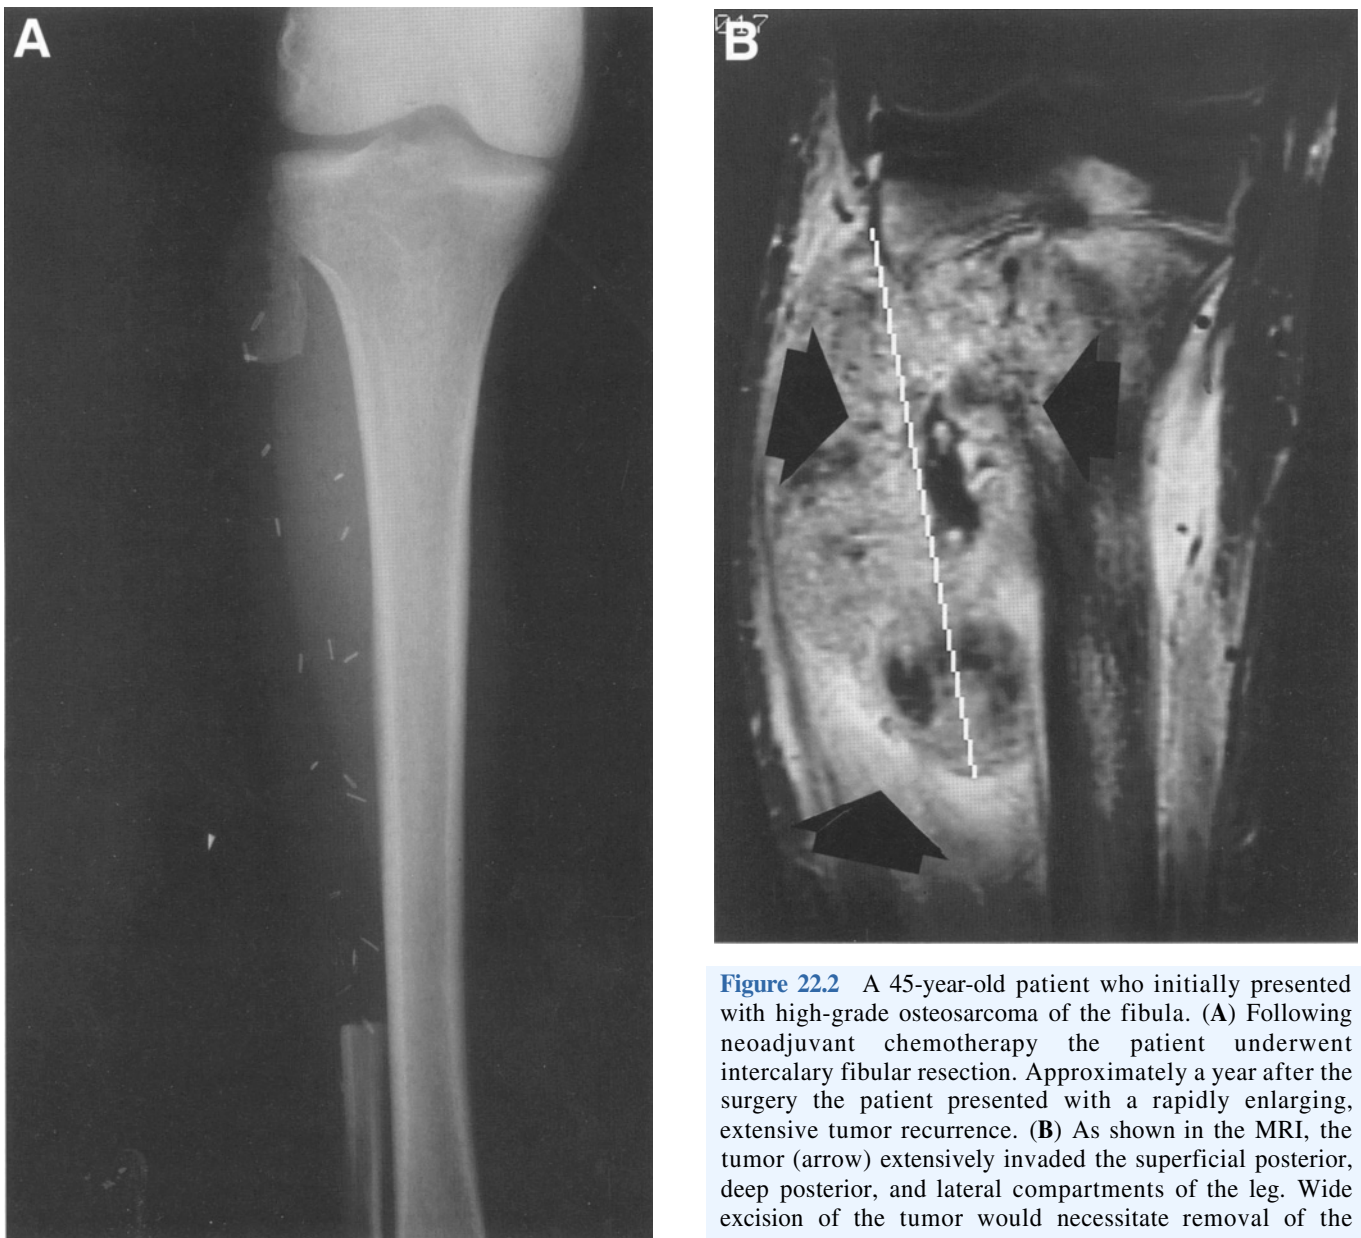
A 45-year-old patient who initially presented with high-grade osteosarcoma of the fibula. (A) Following neoadjuvant chemotherapy the patient underwent intercalary fibular resection. Approximately a year after the surgery the patient presented with a rapidly enlarging, extensive tumor recurrence. (B) As shown in the MRI, the tumor (arrow) extensively invaded the superficial posterior, deep posterior, and lateral compartments of the leg. Wide excision of the tumor would necessitate removal of the neurovascular bundle and all three compartments. Above-knee amputation was therefore performed.
